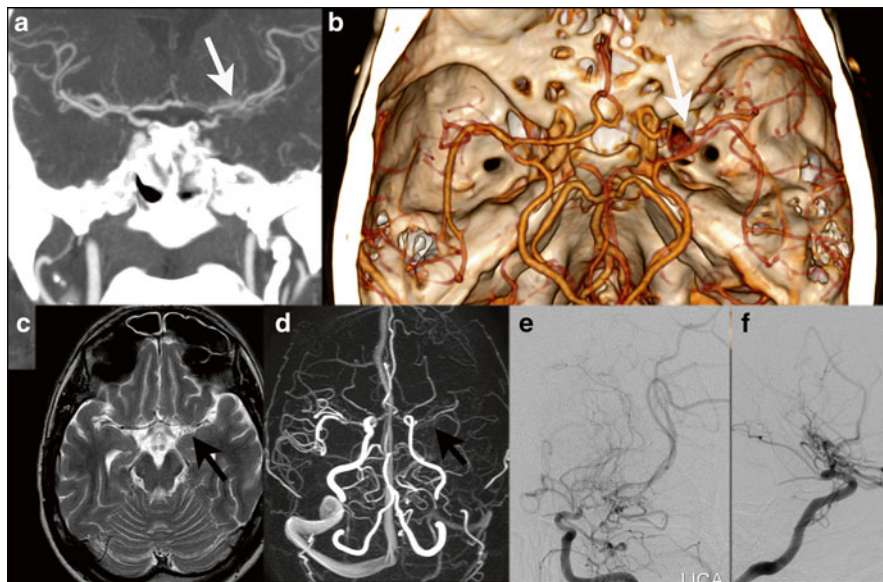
A 37 y/o male initially presented with bilateral anterior thalamic infarcts as well as multiple infarctions in both hemispheres. CTA shows occlusions of the left A1 and M1 segments with collateral vessels (a, MIP; b, VR; *white arrows*). MR T2-weighted imaging demonstrates flow voids (c, *black arrow*) in these collaterals. MRA suggests occlusion of the left MCA (d). DSA confirms occlusions of the M1 and A1 segments with collaterals via the lenticostriatal arteries (e, f). These findings are consistent with Moyamoya disease
